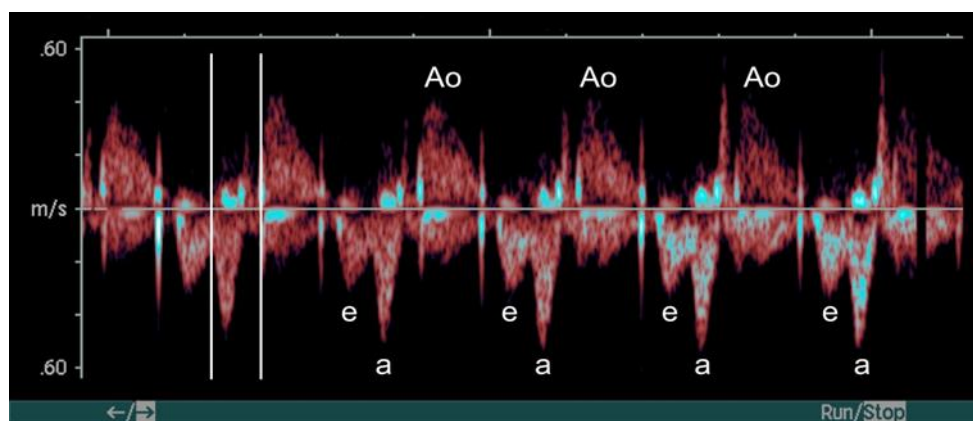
Doppler recording from the left ventricular inflow (mitralis) and left ventricular outflow (aorta). The hemodynamic results of the atrial contractions (A wave) are marked with a. The Atrioventricular (AV) time interval is measured from the intersection of the E- and A waves to the beginning of the ejection wave of the aortic outflow.
